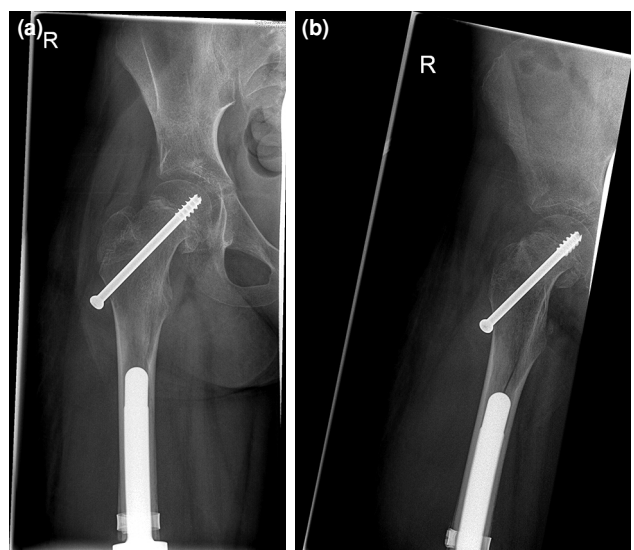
Acute SCFE that was treated by closed reduction and screw fixation. (a) Anteroposterior radiograph (b) lateral radiograph. SCFE: Slipped capital femoral epiphysis.
